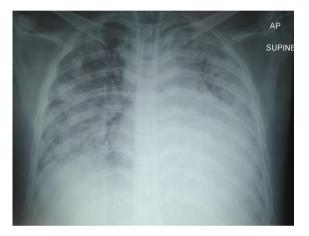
Chest X-Ray on day 2 of admission.
